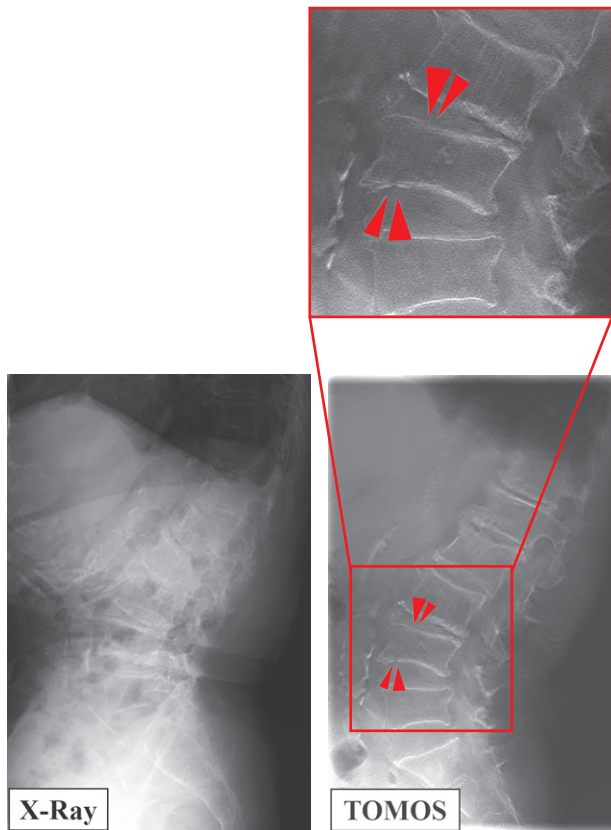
Radiography and TOMOS Lateral Views during Initial Examination of an 80-year-old Woman
